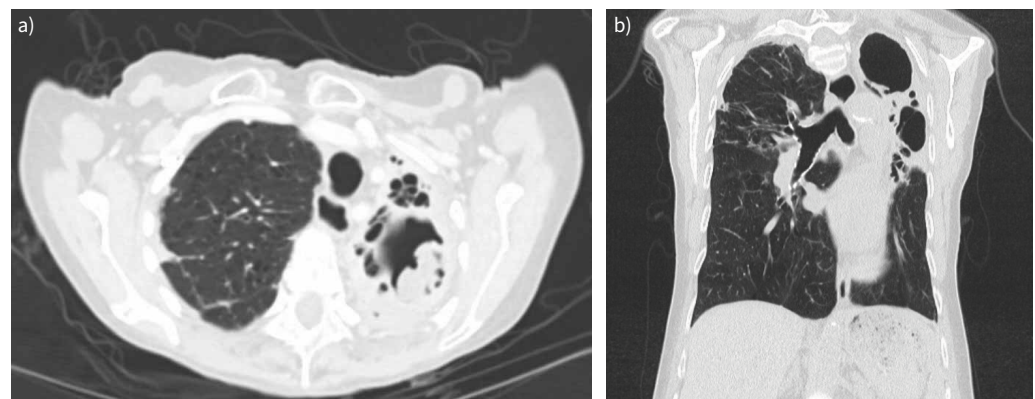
a) Computed tomography (CT) of the chest in 2020, the axial view shows progressive destruction of lung in the left apex with a fungus ball in a large cavity. b) CT of the chest in 2023, the coronal view shows progressive destruction of the left upper lobe, pleural thickening and bronchiectasis.
